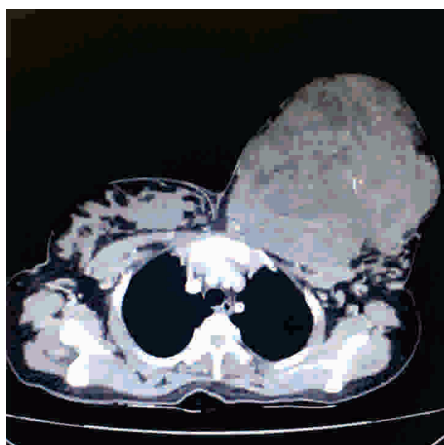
Chest Computed Tomography Showing Heterogenous Mass Infiltrating the Left Pectoralis Major.
